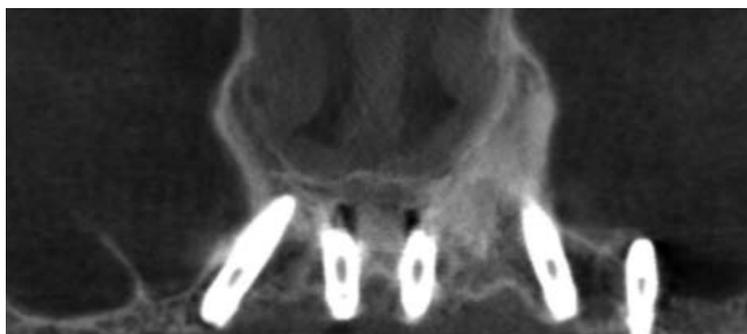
Postoperative CBCT showing final implant position.
